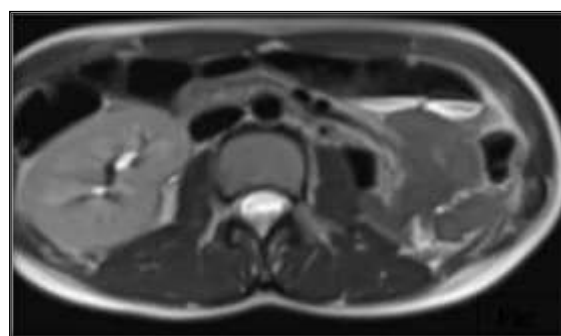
Axial T2 MRI showing absent left kidney.
